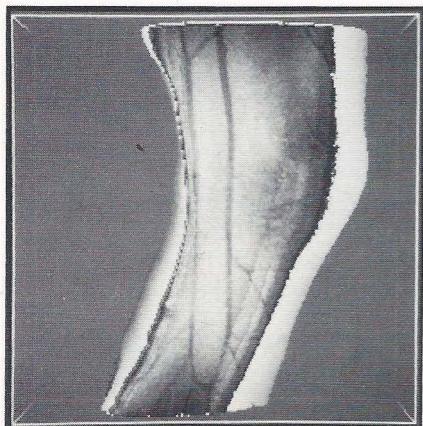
Selective transparent projection. Left: Layer of 1 cm along a knee (MRI, case 4). Right: Layer of 0.5 cm along the surface of a head (MRI, case 2).
